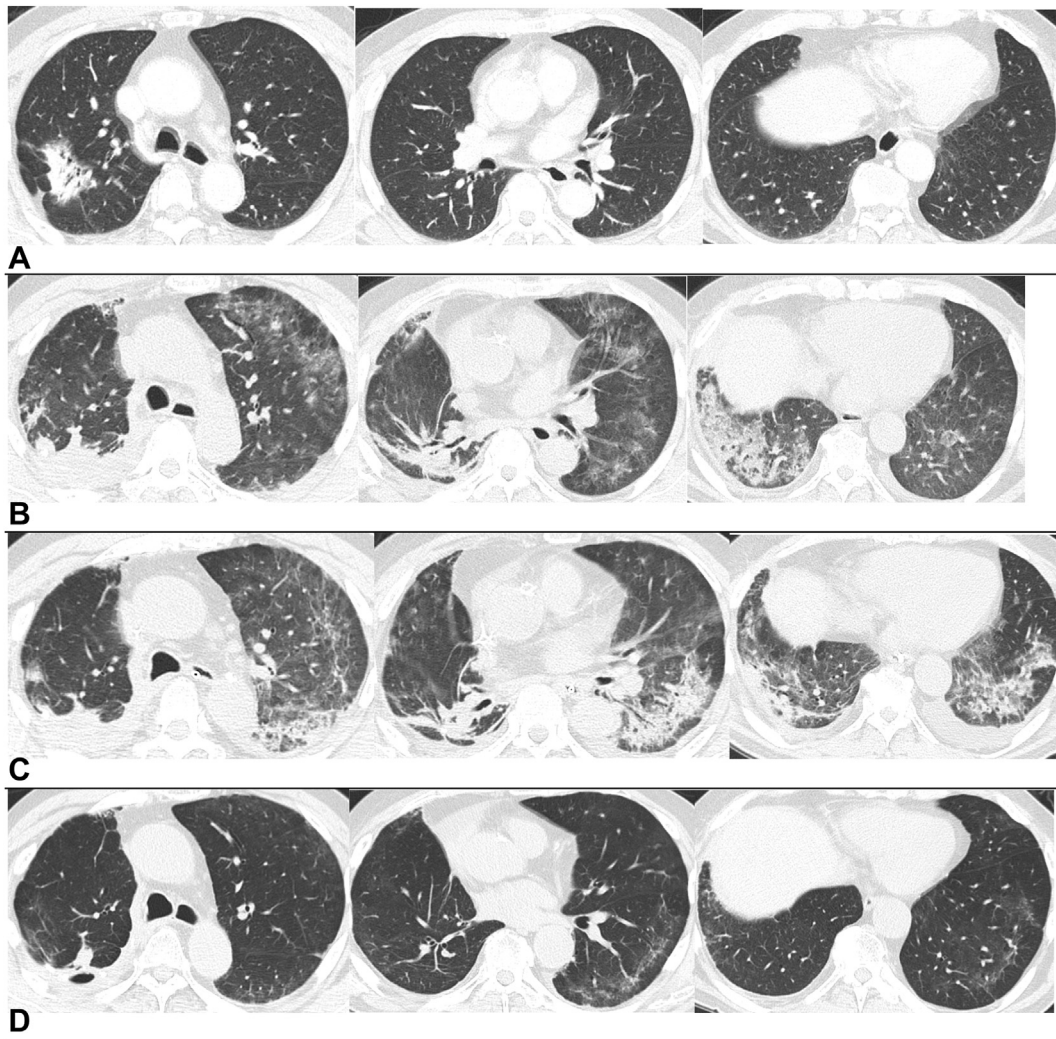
Chest CT scans obtained from before the administration of osimertinib to discharge. (A) A preoperative CT scan (day 103) revealed no evidence of interstitial shadowing. (B) The CT scan obtained on day 44 of admission revealed light pleural effusion, diffuse ground-glass opacities in the left lobe, and consolidation in the right lower lobe. Traction bronchiectasis was observed, and the subpleural area was preserved. Given the widespread ground-glass opacities and consolidation, along with partial bronchiolar dilation and architectural changes, a DAD pattern was diagnosed. (C) Images obtained on day 51 revealed bilateral pleural effusion, extensive consolidation, and ground-glass opacities. (D) On day 92, the consolidation disappeared, leaving only residual linear shadows. CT, computed tomography; DAD, diffuse alveolar damage.
